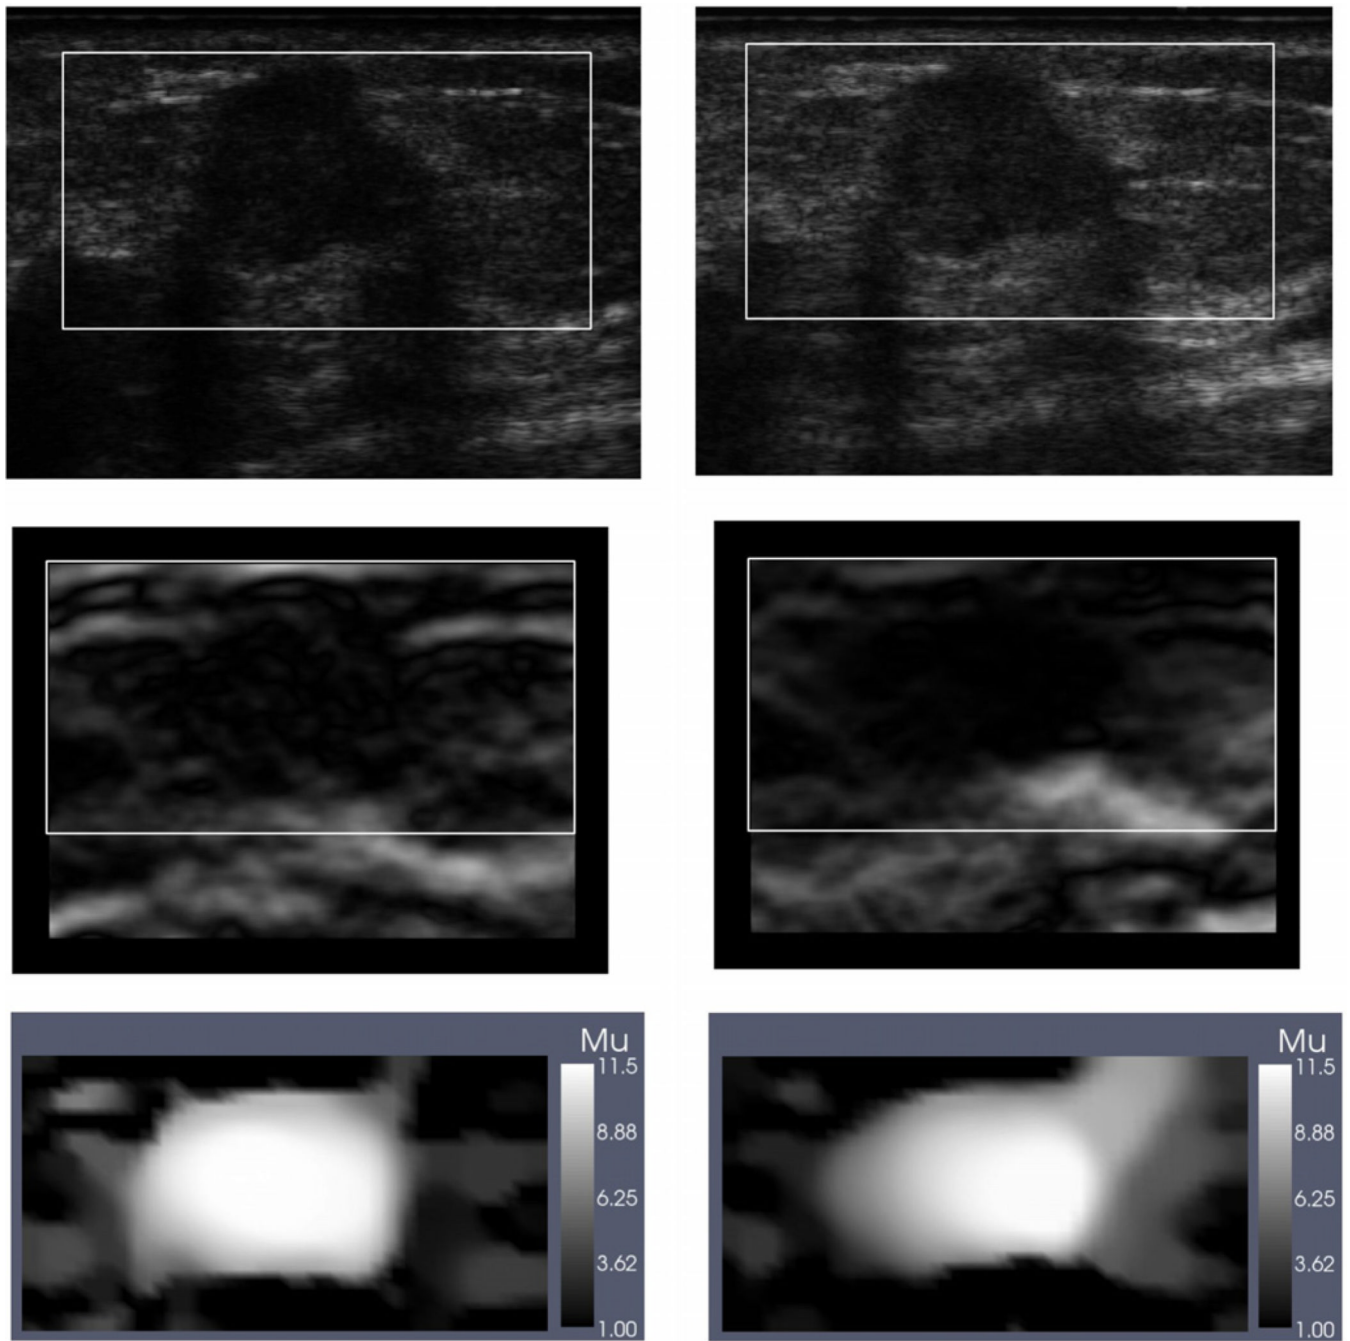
Images for infiltrating ductal carcinoma (IDC). Left column: images at small strain; right column: images at large strain. Top row: B-mode ultrasound images; middle row: axial strain image; bottom row: relative shear modulus (secant) images.
